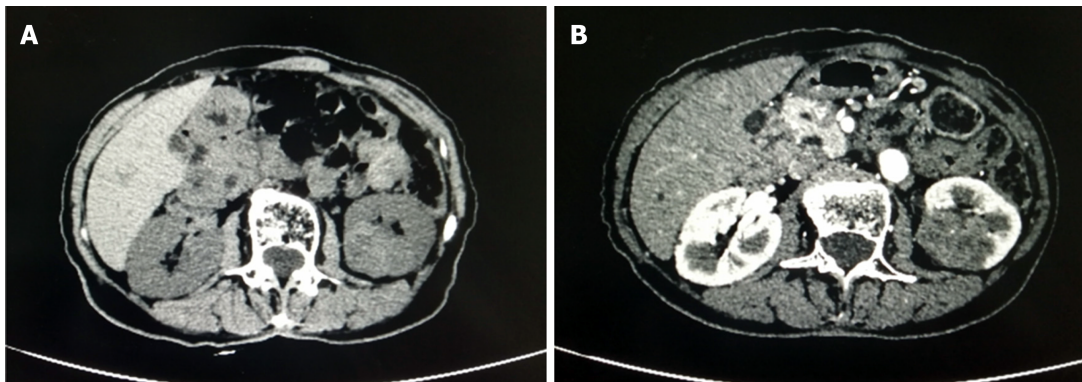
Pre-operative computed tomography images. A: Computed tomography (CT) image showing a 4.1 cm × 3.2 cm mass in the middle pole of the left kidney. B: Contrast-enhanced CT image showing slight enhancement.
